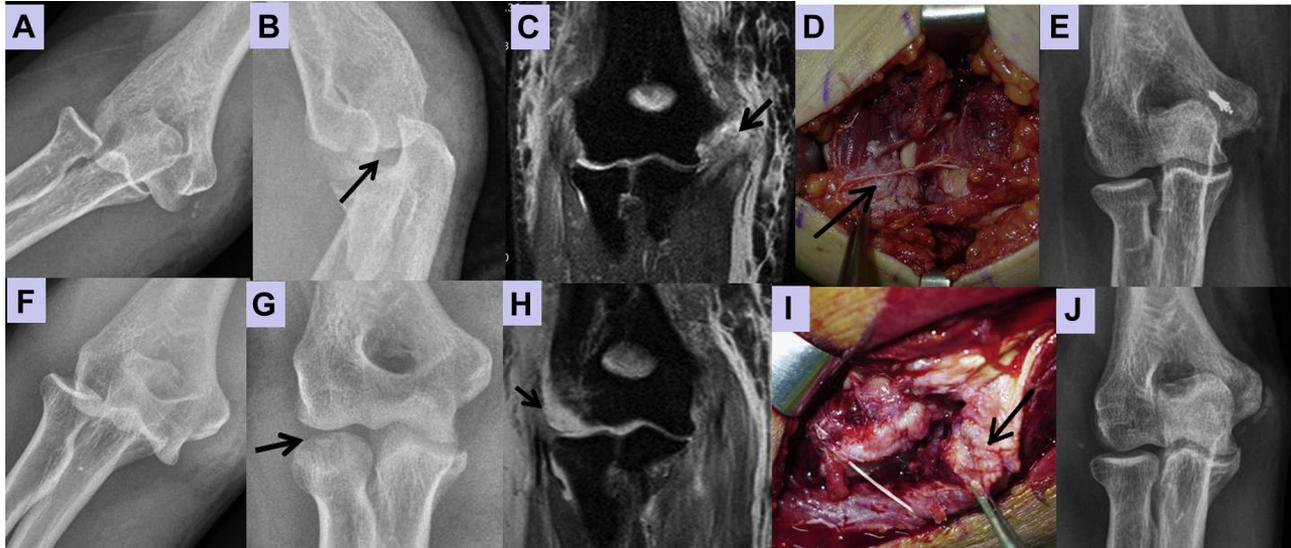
(A-E) During unstable posterolateral dislocation, a widening of the ulnohumeral joint space (B, →) after closed reduction is observed. A complex dual lesion of the medial side (C, →) is detected on T2-weighted fat-suppression coronal view of magnetic resonance scan. Intraoperative finding is consistent with this finding (D, →). A stable elbow joint was observed after medial-side repair (patient 18). (F-J) Another case of this type of injury (patient 23) shows widened radiocapitellar joint, suggesting unstable elbow joint after closed reduction (G, →). The stripped and displaced lateral collateral ligament complex and overlying extensor muscles from the original attachment site of lateral epicondyle are seen on T2-weighted coronal magnetic resonance scan (H, →). Intraoperative finding is compatible with this finding (I, →). A stable elbow joint was observed after only lateral-side repair, where the soft anchor was used and not detected in a simple radiograph (J).
